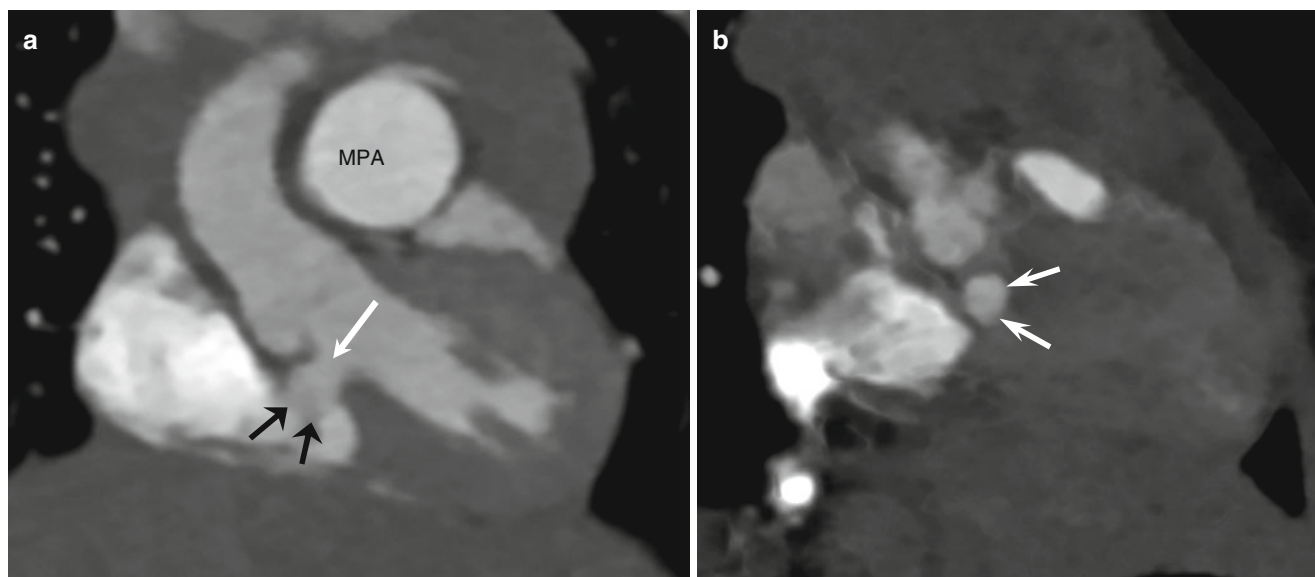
Ventricular septal defect. Coronal CT image demonstrates a perimembranous ventricular septal defect (*long arrow*) with septal aneurysm (*short arrows*) (a). The dilated main pulmonary artery (*MPA*)
